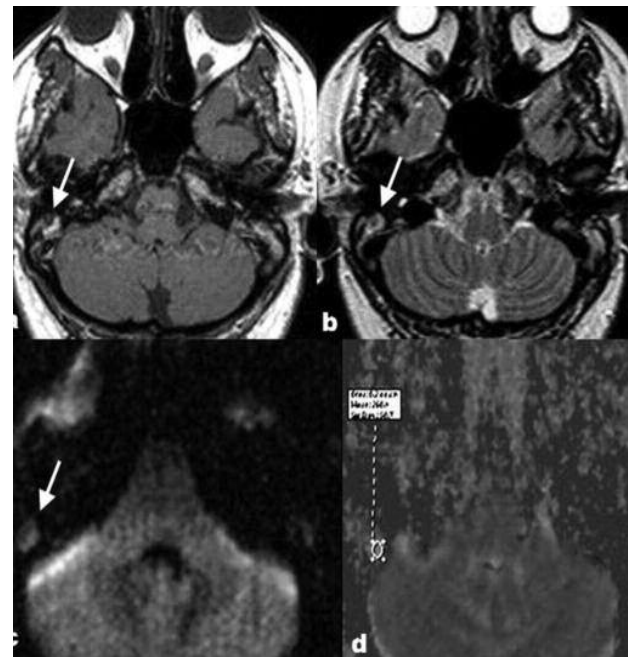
case of bilateral Chronic Otitis Media. MRI shows T1 hypointense (arrow, a) and T2 hyperintense (arrow, b). DWI shows isointensity in this same area (arrow, c). ADC value was measurement $2,56 \times 10^{-3} \text{ mm}^2/\text{sec}$ (d).
